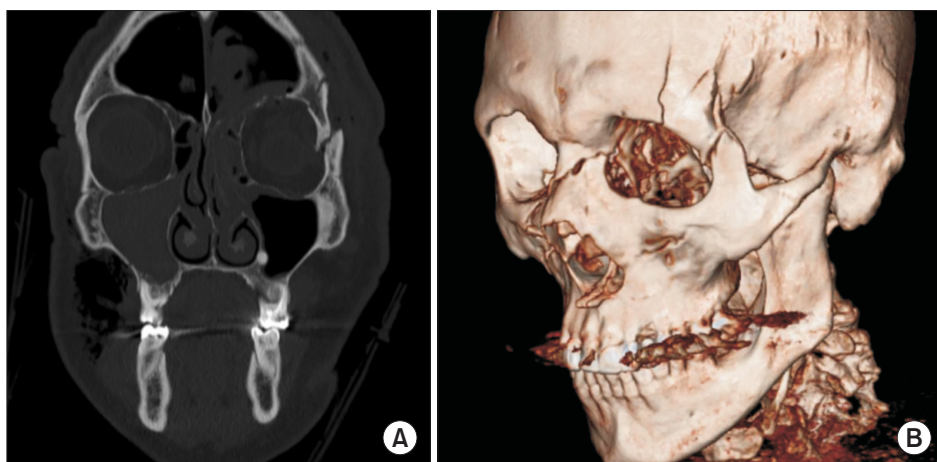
Preoperative (A) computed tomography scan and (B) three-dimensional reconstruction showing left fronto-orbito-zygomatic fracture with intermediate segment.
